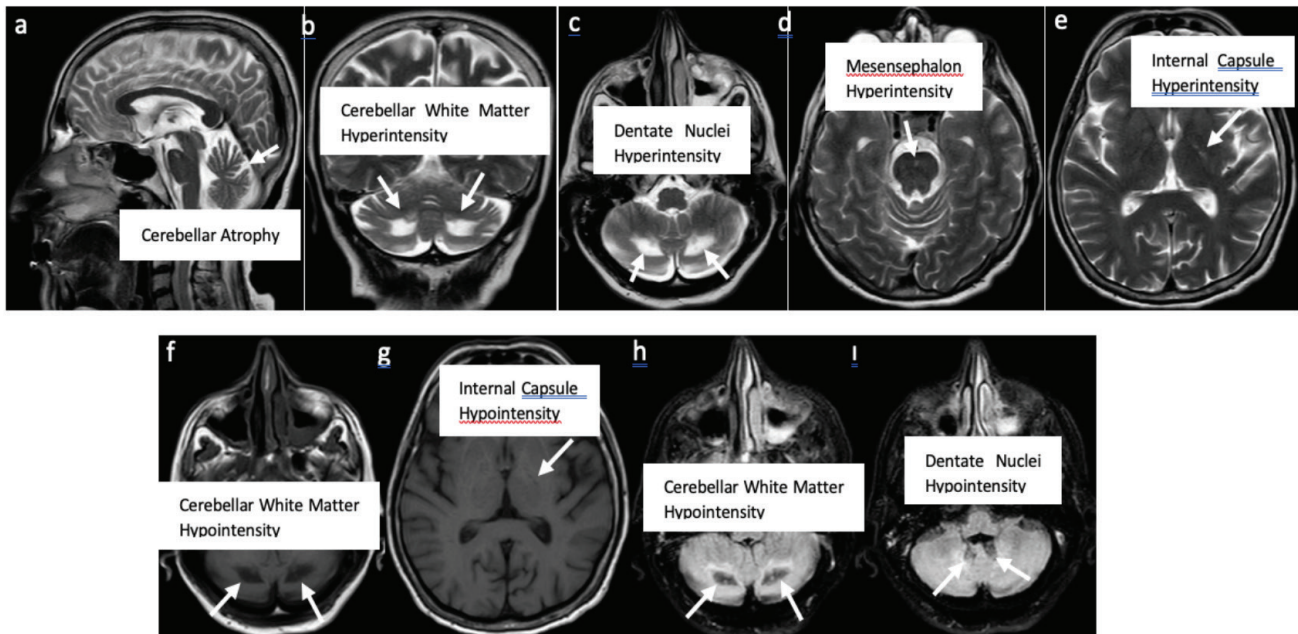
a) Cerebellar atrophy. b-e) Hyperintense lesions on T2-weighted imaging in the deep cerebellar white matter, dentate nuclei, anterior of the mesencephalon and posterior limb of the left internal capsule. f, g) Hypointense lesions on T1-weighted imaging in the deep cerebellar white matter and posterior limb of the left internal capsule. h, i) Hypointensity areas in the deep cerebellar white matter and dentate nuclei on FLAIR imaging
